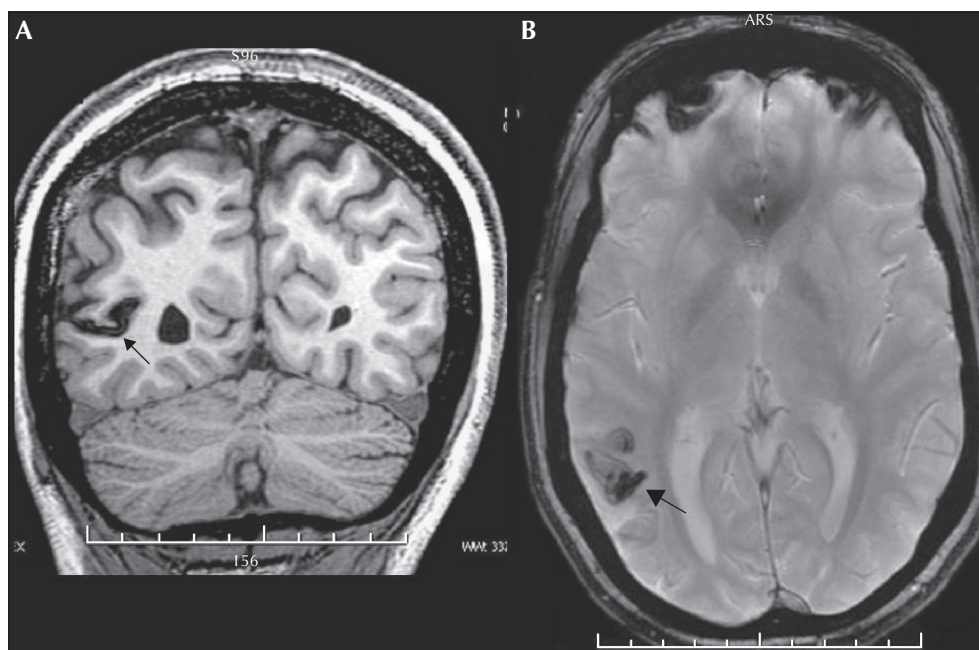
MRI 3.0T epilepsy protocol. A) Coronal 3D showing linear hypointensity (arrow). B) T2* right temporo-parieto-occipital hypointense image (arrow).
